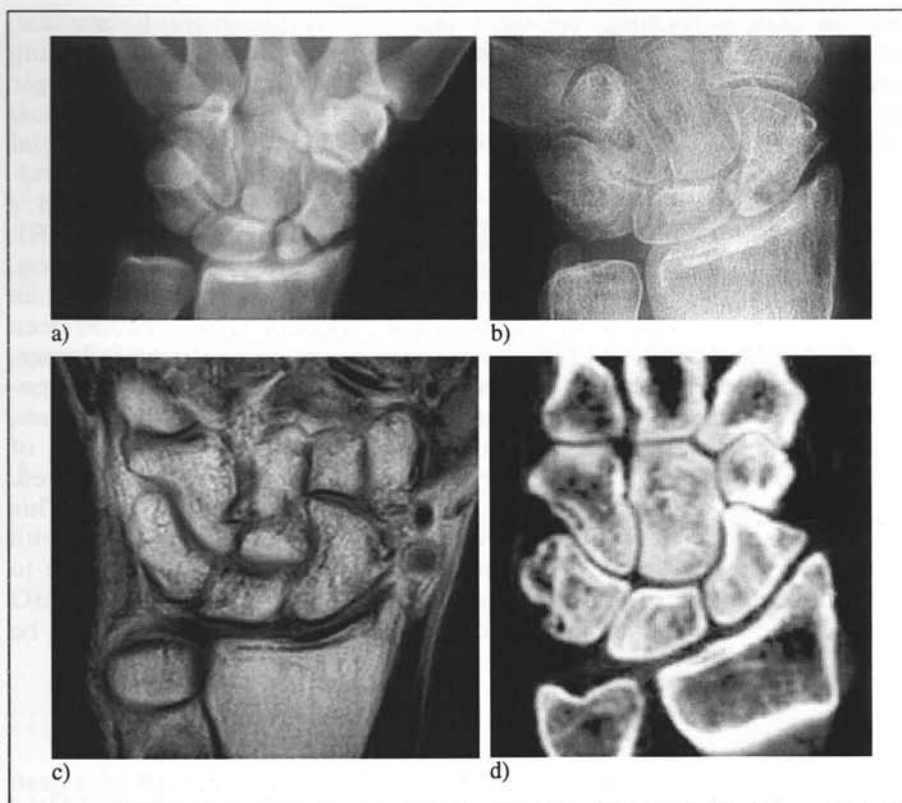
Scaphoid non-union with a necrotic proximal pole (a), successfully healed (b). Normal contrast uptake can be observed three years later with gadolinium-enhanced MRI (c). MPR-CT scan shows complete reconstruction (d).
